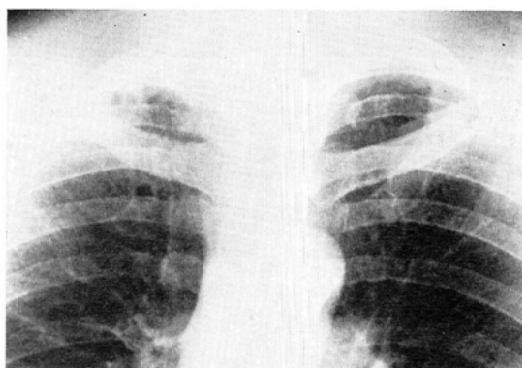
Y 6611. An apparent cavity in the upper lobe of the right lung, later radiographically proven to be a defect in the costochondral junction of the first rib.
